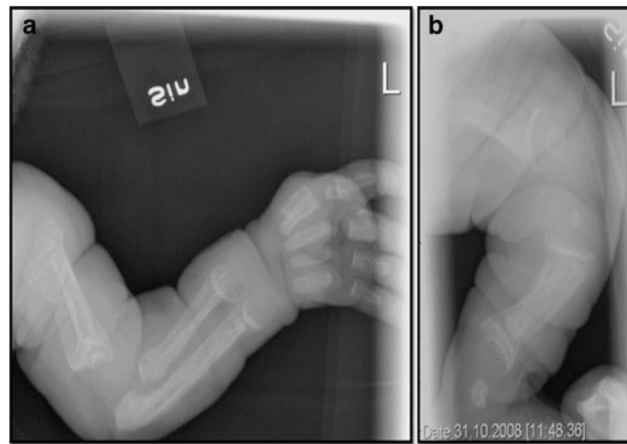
X-rays of left arm (a) and left leg (b) at birth. In both X-rays, shortening of bones, osteopenia, and a bone-in-bone appearance are seen. The metaphyses are expanded with cupping and fraying
